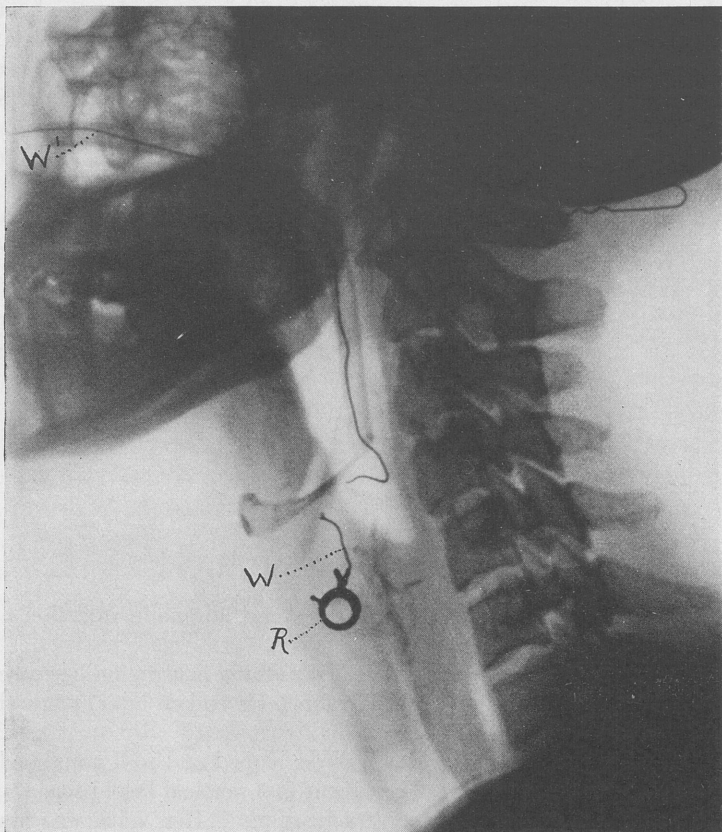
Lateral roentgenogram, showing spring ring anchored in the laryngeal web.
